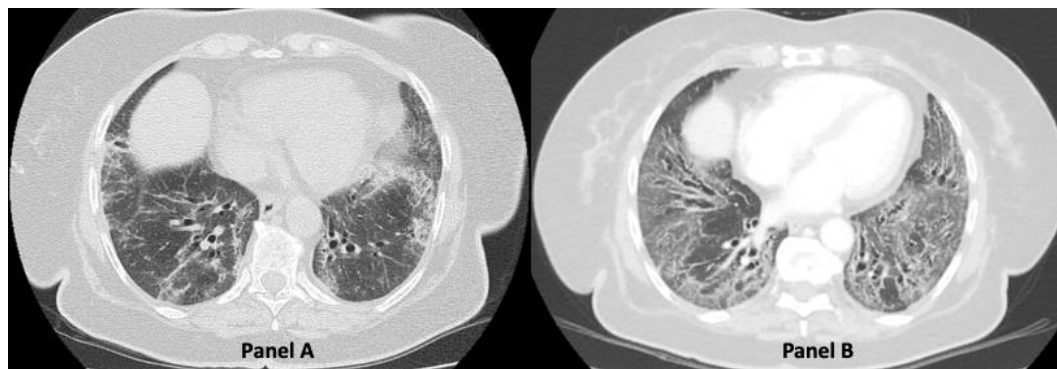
Radiologic progression after one year of treatment. CT images of a 77 years old woman at baseline (Panel A) and after the first year of treatment (Panel B) showing radiological features consistent with progression.
